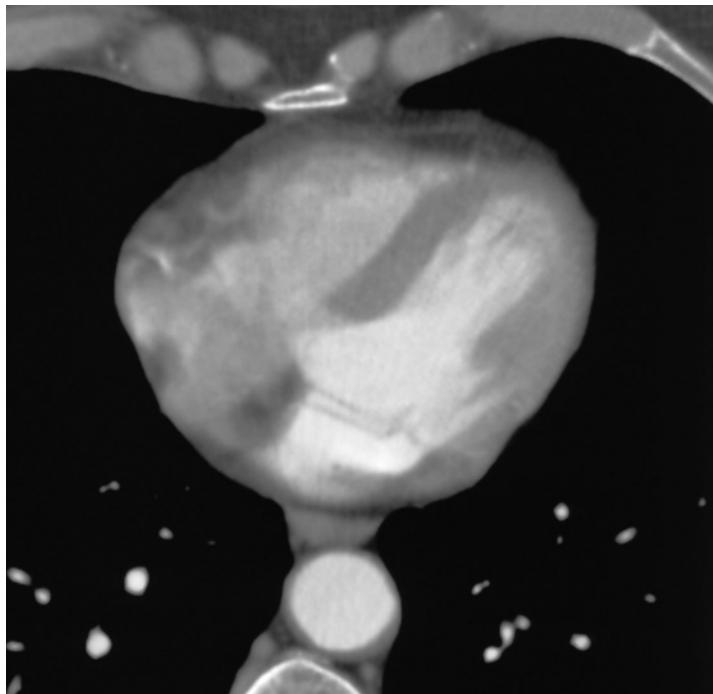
Visualization of the cardiac chambers on CT. The image clearly demonstrates the physiologic mismatch between the thick wall of the left ventricle and the fine wall of the right ventricle, which is normally practically invisible.
